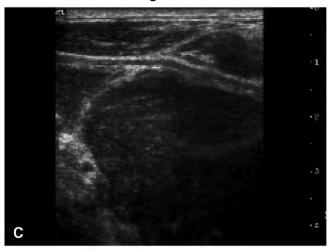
Ultrasound of lymphoma in the right lobe. A, Transverse, 30×40 mm. B and C, Longitudinal.
